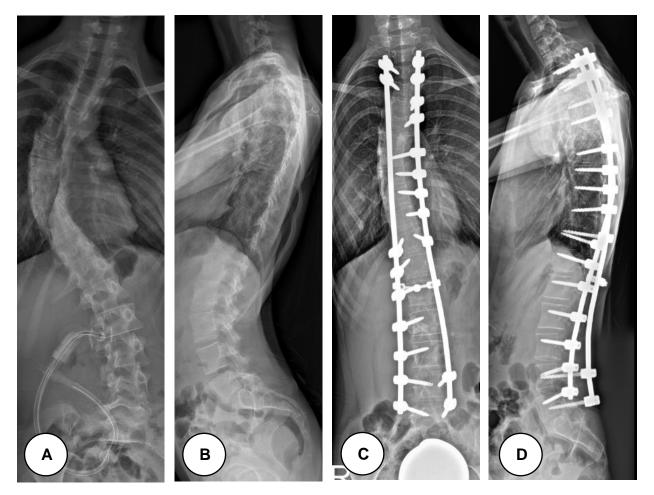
Pre- and postoperative spinal radiographs of a 12-year-old female with neuromuscular scoliosis. Preoperative ap view (A) shows a main thoracal dextroconvex curve with an MCA of 67 degrees and a C7-offset of 10 degrees spanning from the fifth to the eleventh thoracal vertebra. Preoperative lateral view (B) shows a thoracal kyphosis of 38 degrees and a lumbar lordosis of 74 degrees. Postoperative ap view (C) visualizes a dual-rod construct with a transverse connector at the second lumbar vertebral level. Fusion length is 16 levels with a total of 20 screw anchors corresponding to an anchor density of 1.25 screws per level. MCA is reduced to 30 degrees with a curve correction of 55 percent. Thoracal kyphosis and lumbar lordosis are reduced to 17 and 43 degrees respectively, as seen in the postoperative lateral view.(D) ap = anteroposterior, MCA = major curve angle
